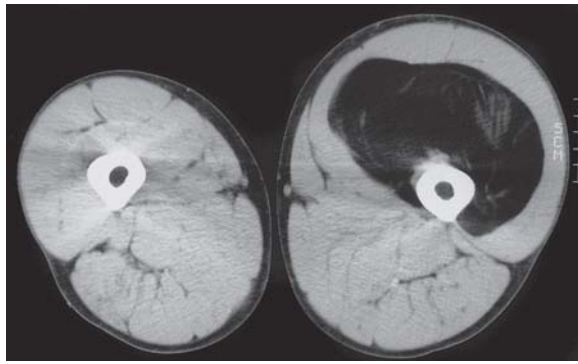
Benign lipoma in the left anterior thigh of a 26-year-old man. Using computed tomography, a few fibromuscular septa can be identified traversing the lipoma
